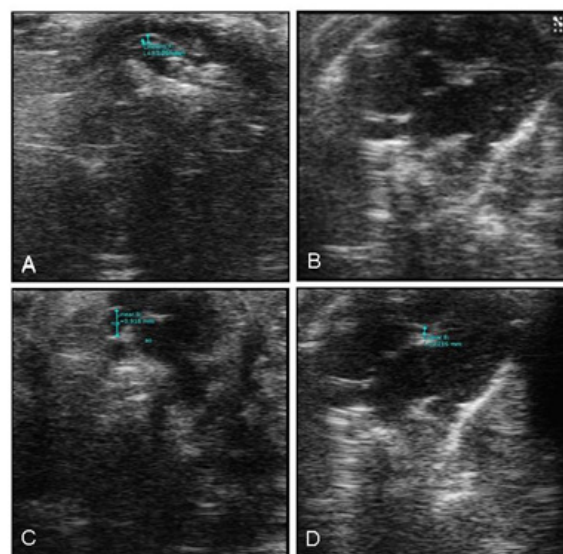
Echocardiogram.
